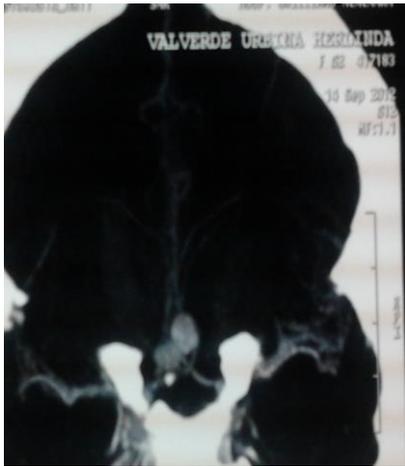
Cerebral Angio-CT showing a bilobed anterior communicating artery aneurysm.
